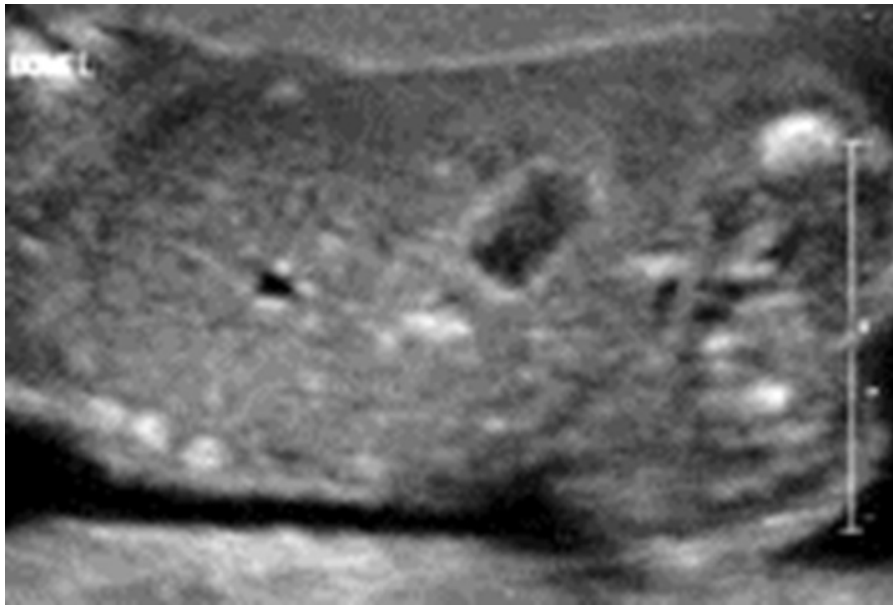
Bowel Calcifications. Ultrasound (Coronal/Oblique plane).
